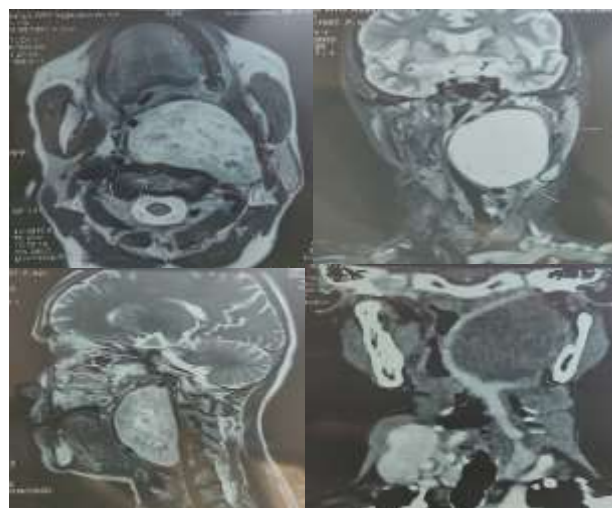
CT and MRI pictures showing extent of the tumour till skull base and causing airway compromise.
